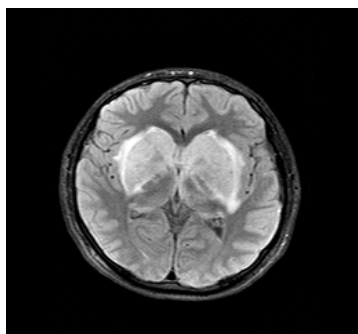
Axial FLAIR MRI series show hyperintensities in bilateral basal ganglia
